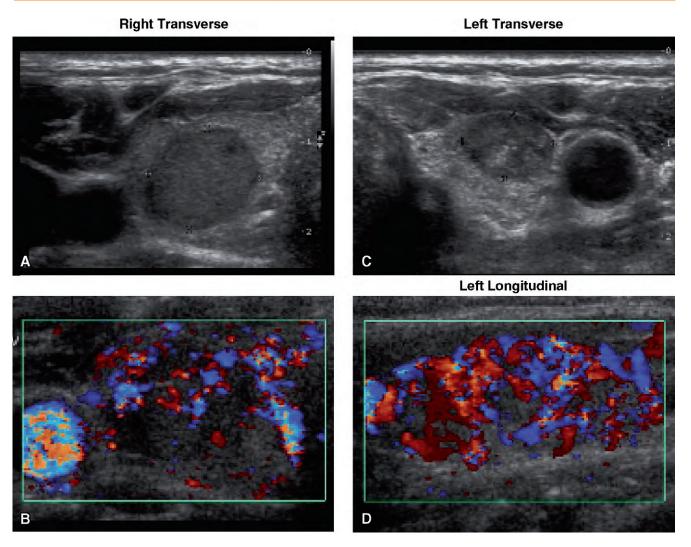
Ultrasound of medullary thyroid carcinoma in the right lobe. A, Right transverse, 10 x 12 mm. B, Color Doppler, right transverse. C, Left transverse, 7 x 10 mm. D, Color Doppler, left longitudinal.
